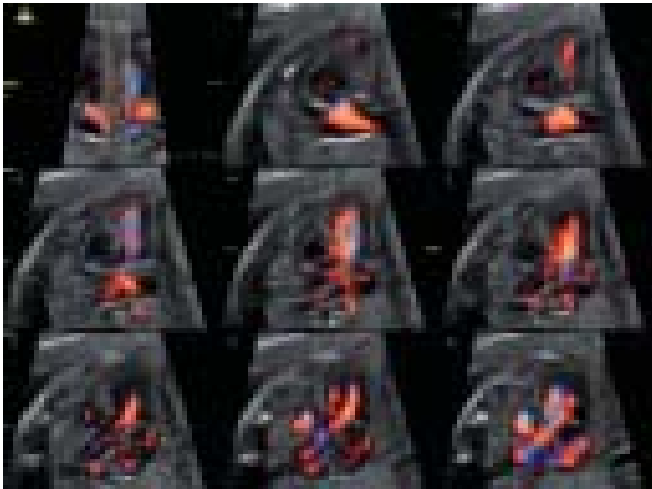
Tomographic ultrasound imaging with color Doppler—static image correlation volume data set of the left and the right ventricular outflow tracts
